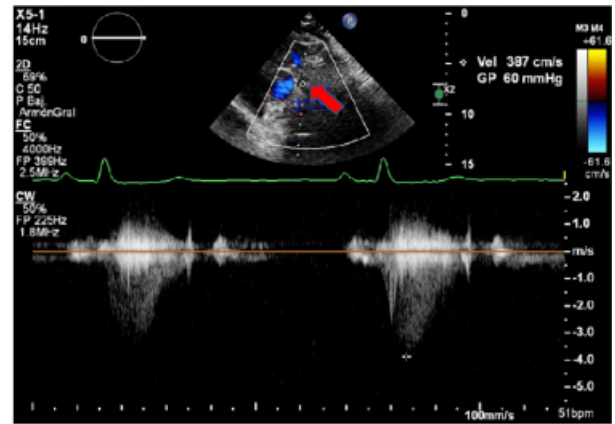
Continuous Doppler of pulmonary valve level showing severe sub-valvular stenosis with a peak gradient of 60 mmHg.
